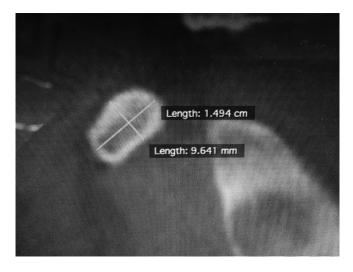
Computed tomography–guided measurements for the medial-lateral and superior-inferior dimensions of the coracoid.
